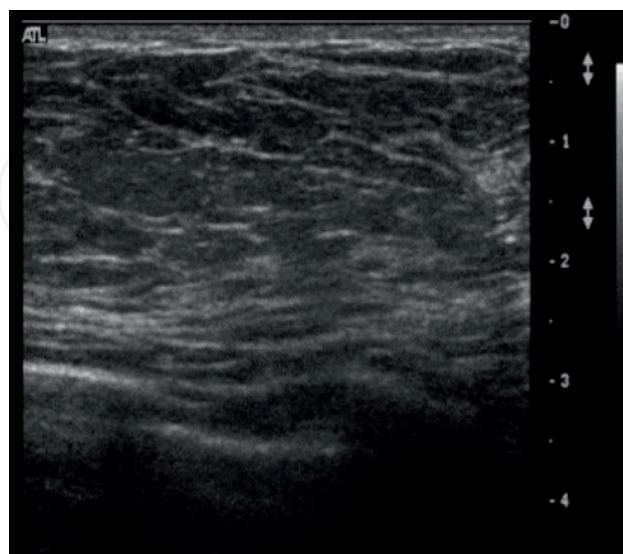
Homogenous background echotexture—fat. Transverse ultrasound demonstrates fat lobules, with uniform echogenic bands of supporting structures making up the bulk of the breast tissue.
